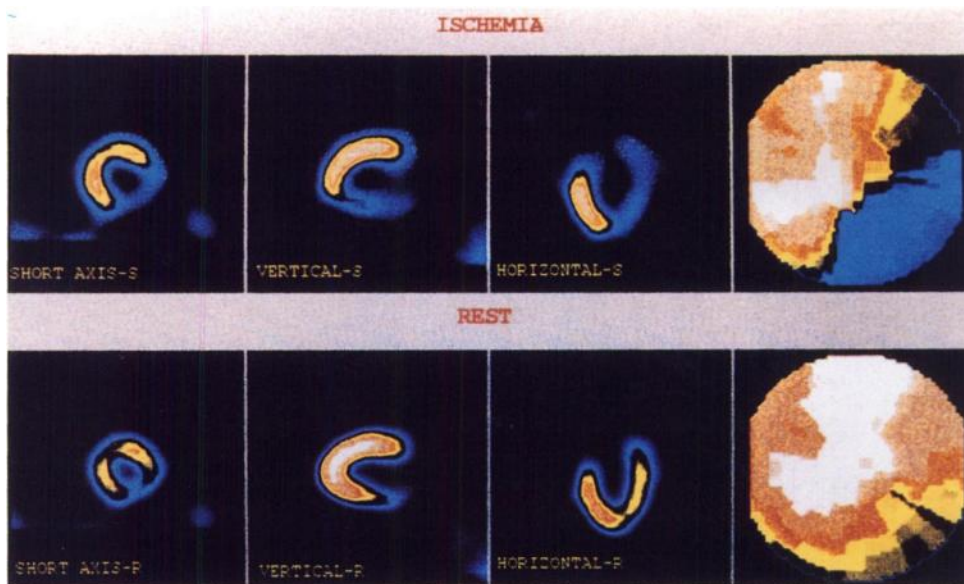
Technetium- $^{99\text{m}}\text{Tc}$ -sestamibi SPECT images obtained during spontaneous myocardial ischemia (ischemia) and at rest (rest) 72 hr later. Defects were seen in the inferolateral and inferoposterior walls with normalization on the rest images and a residual inferior defect. Bullseye reconstruction confirms an inferolateral defect with marked improvement upon rest imaging.
